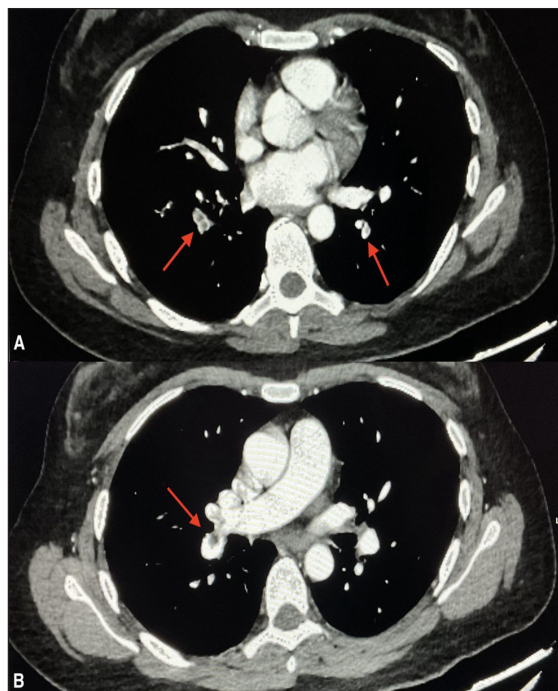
Coronal computed tomography pulmonary angiography showing segmental filling defects in the pulmonary artery branches of both upper and lower lobes: (A) filling defects in the segmental branches of the pulmonary artery are suggestive of thrombus (red arrows) and (B) eccentric filling defect in the interlobar artery (red arrow).
